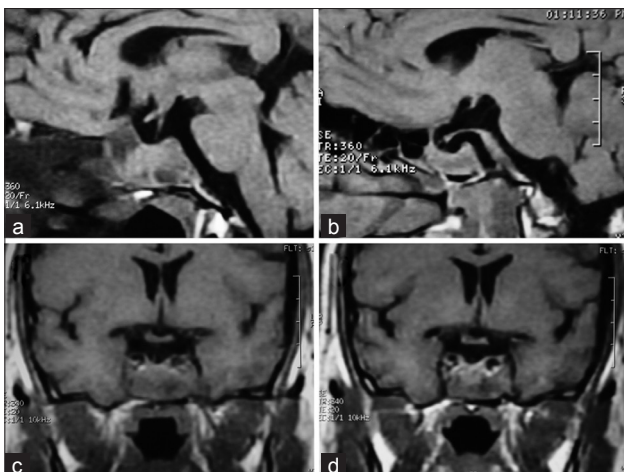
(a, c) Sagittal and coronal T1-weighted MRI brain scan showing a sphenoidal sinus tumor. (b, d) Sagittal and coronal contrast-enhanced T1-weighted MRI showing a sphenoidal sinus tumor with heterogeneous contrast enhancement
